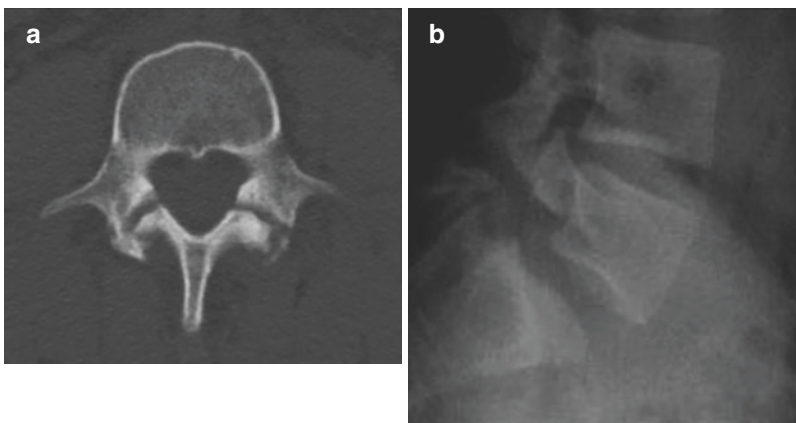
(a) CT scan with bilateral spondylolysis (b) lateral radiographic study with L5-S1 spondylolisthesis
